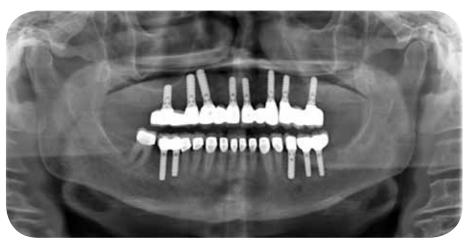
Final panoramic X-ray.
